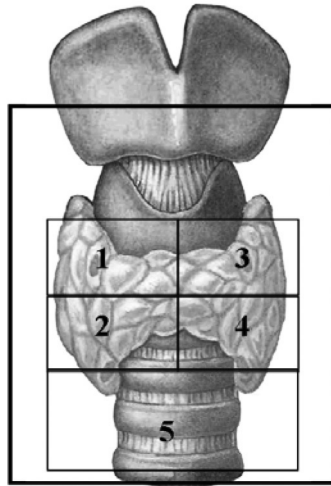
Analysis of the ability of SVS and Tc99m-MIBI-SPECT scan to correctly localize a pathological parathyroid gland as confirmed by localization at surgery by dividing the neck into 5 anatomical areas (the four thyroid quadrants and a 5th area of all possible ectopic localizations in the mediastinum).
